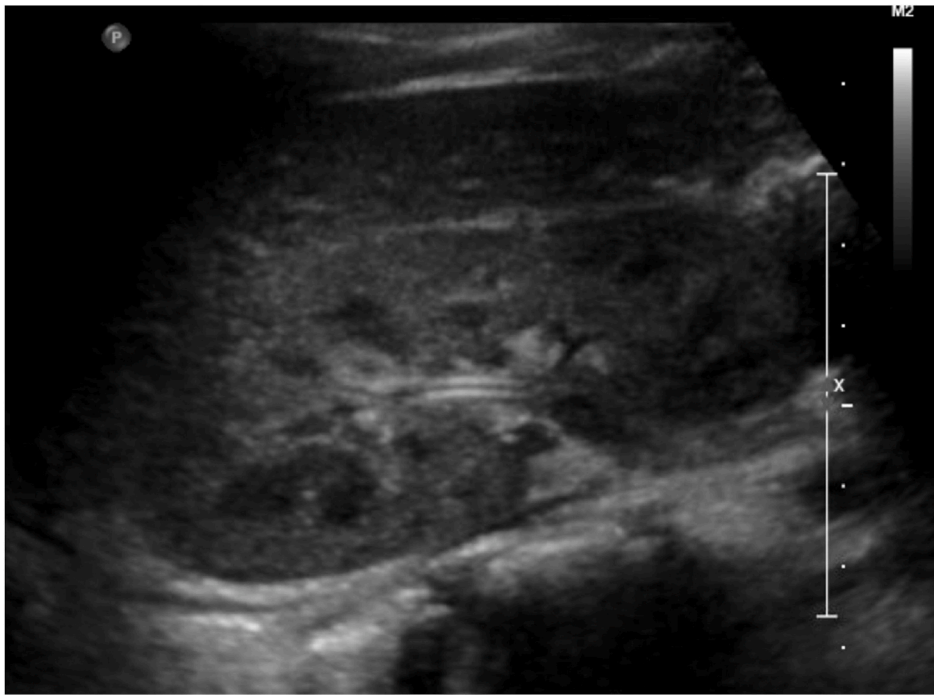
Postoperative longitudinal ultrasound of the right kidney demonstrating stent, resolution of caliectasis, and absence of debris.
